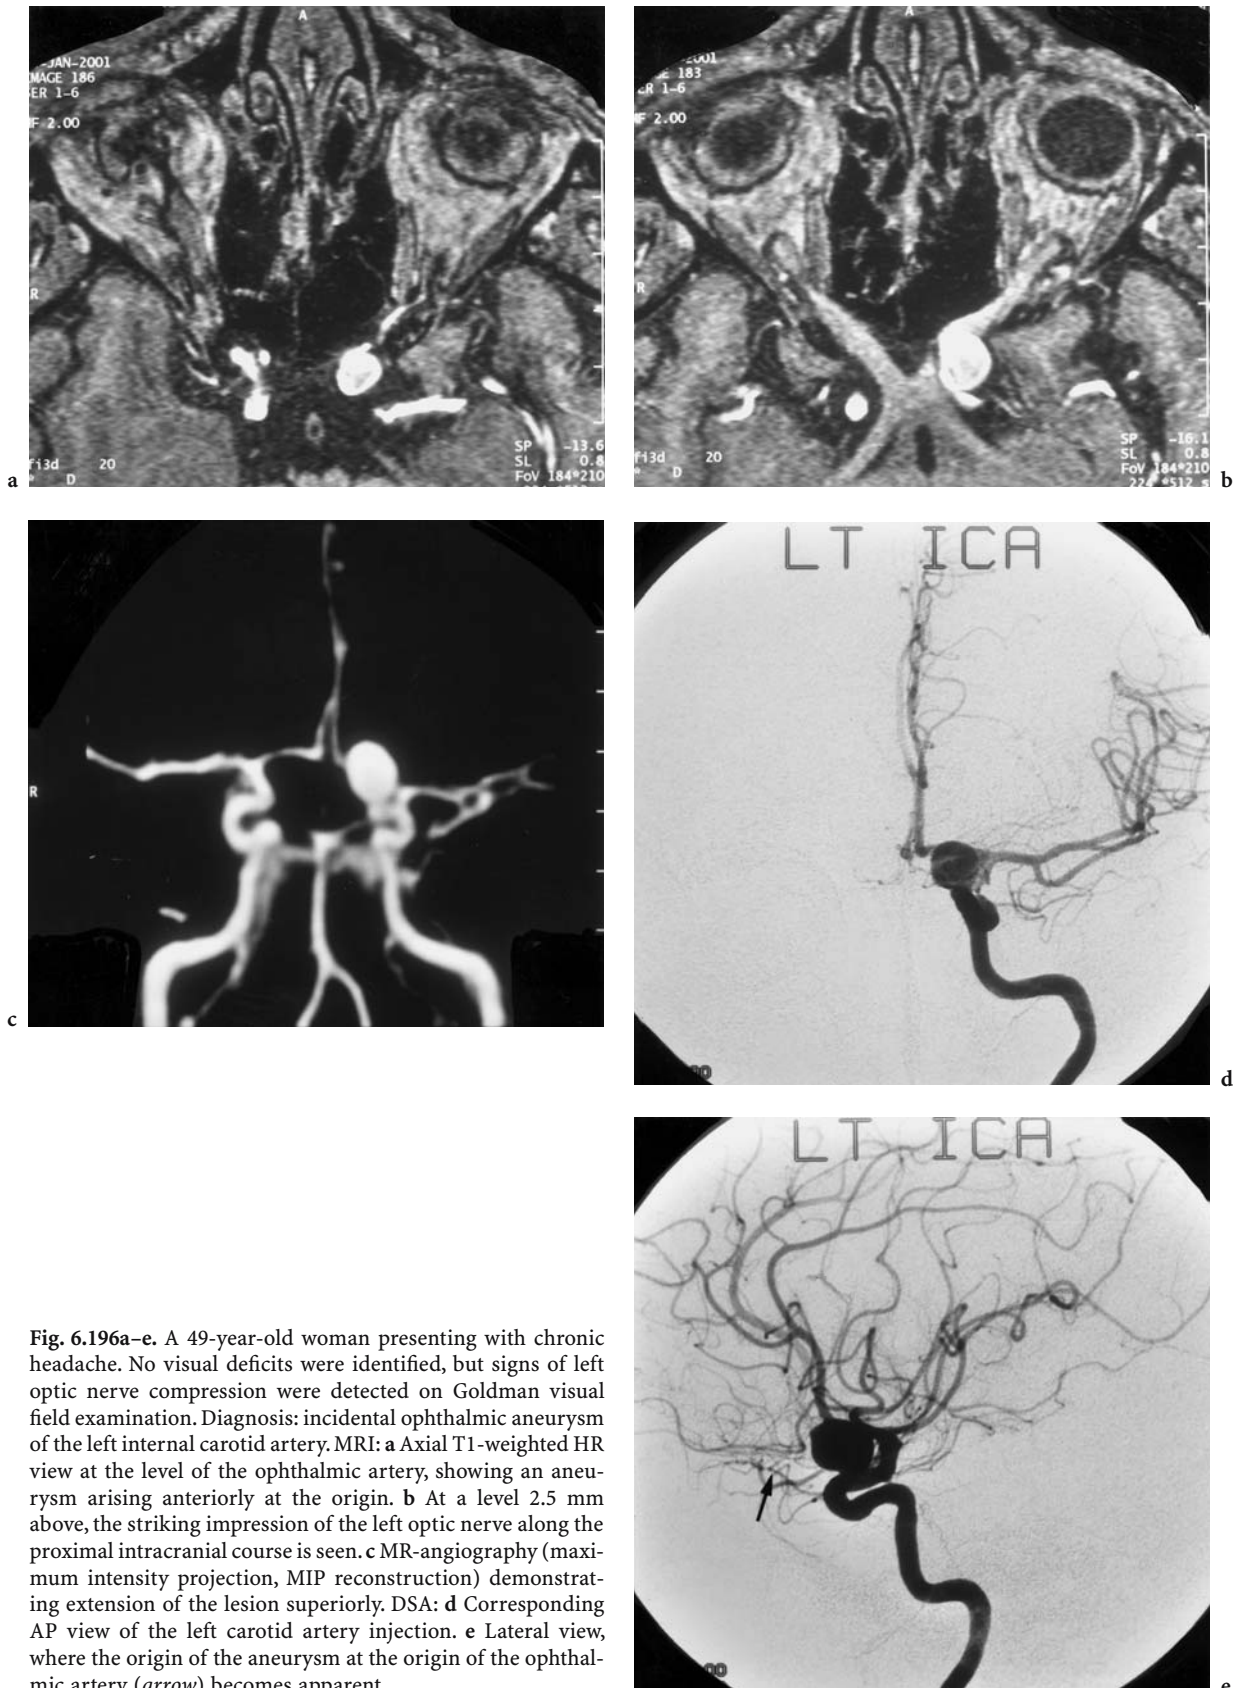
A 49-year-old woman presenting with chronic headache. No visual deficits were identified, but signs of left optic nerve compression were detected on Goldman visual field examination. Diagnosis: incidental ophthalmic aneurysm of the left internal carotid artery. MRI: a Axial T1-weighted HR view at the level of the ophthalmic artery, showing an aneurysm arising anteriorly at the origin. b At a level 2.5 mm above, the striking impression of the left optic nerve along the proximal intracranial course is seen. c MR-angiography (maximum intensity projection, MIP reconstruction) demonstrating extension of the lesion superiorly. DSA: d Corresponding AP view of the left carotid artery injection. e Lateral view, where the origin of the aneurysm at the origin of the ophthalmic artery (*arrow*) becomes apparent
